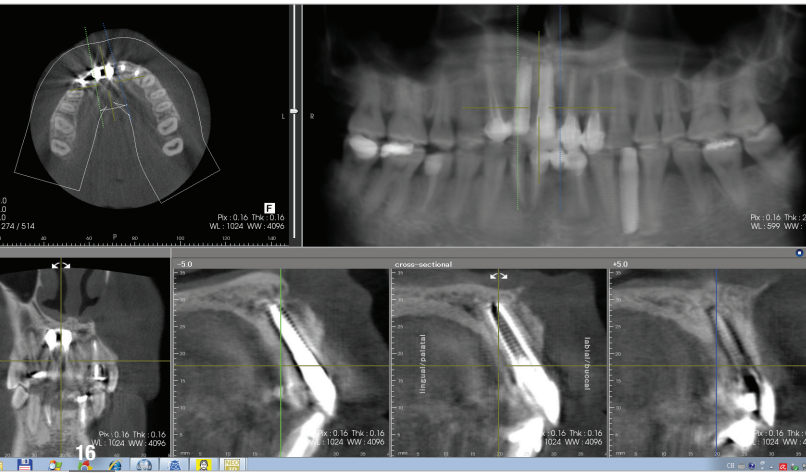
Immediate postoperative panoramic radiograph of the implants and bone grafting at sites #12 and 11. Fig. 17: Retracted view of the immediately placed provisional restorations on implants #12 and 11. Fig. 18: Four-month CT scan confirming buccal bone graft and implant integration at sites #12 and 11.
